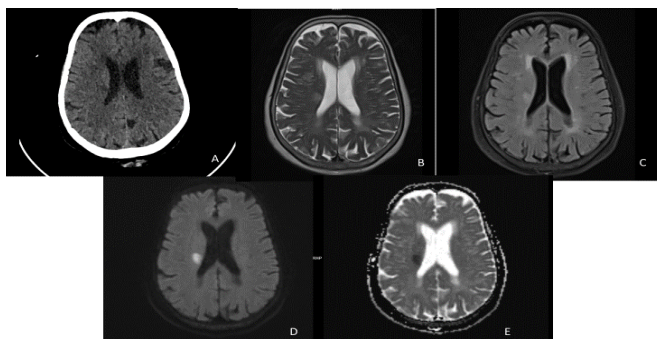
Lacunar infarct. Axial NCCT head shows hypodensity in the right periventricular white matter (a) appearing hyperintense on T2 (b) and flair (c) and showing diffusion restriction on DWI (d) and ADC (e)
